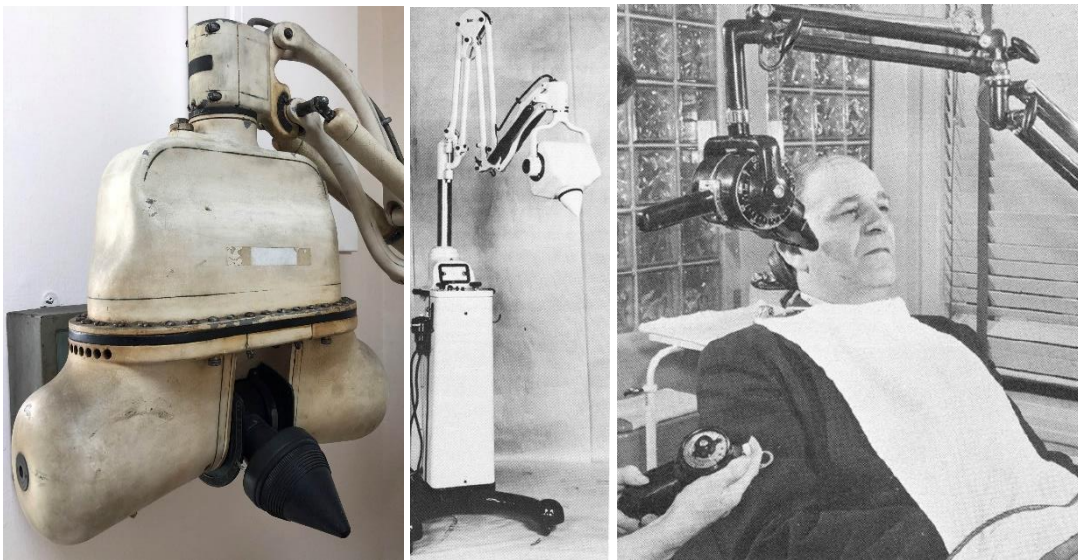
Left: Ritter X-ray unit. Courtesy of P. Pittayapat (Chulalongkorn University). Middle: Weber no. 5 Raydex mobile dental X-ray unit, with a design typical of the late 1930s and 1940s. Right: the compact design of the Philips Oralix X-ray unit (1940s-1950s) allowed it to be attached to the dental chair; it was also produced as a wall-mounted or mobile unit [52].
